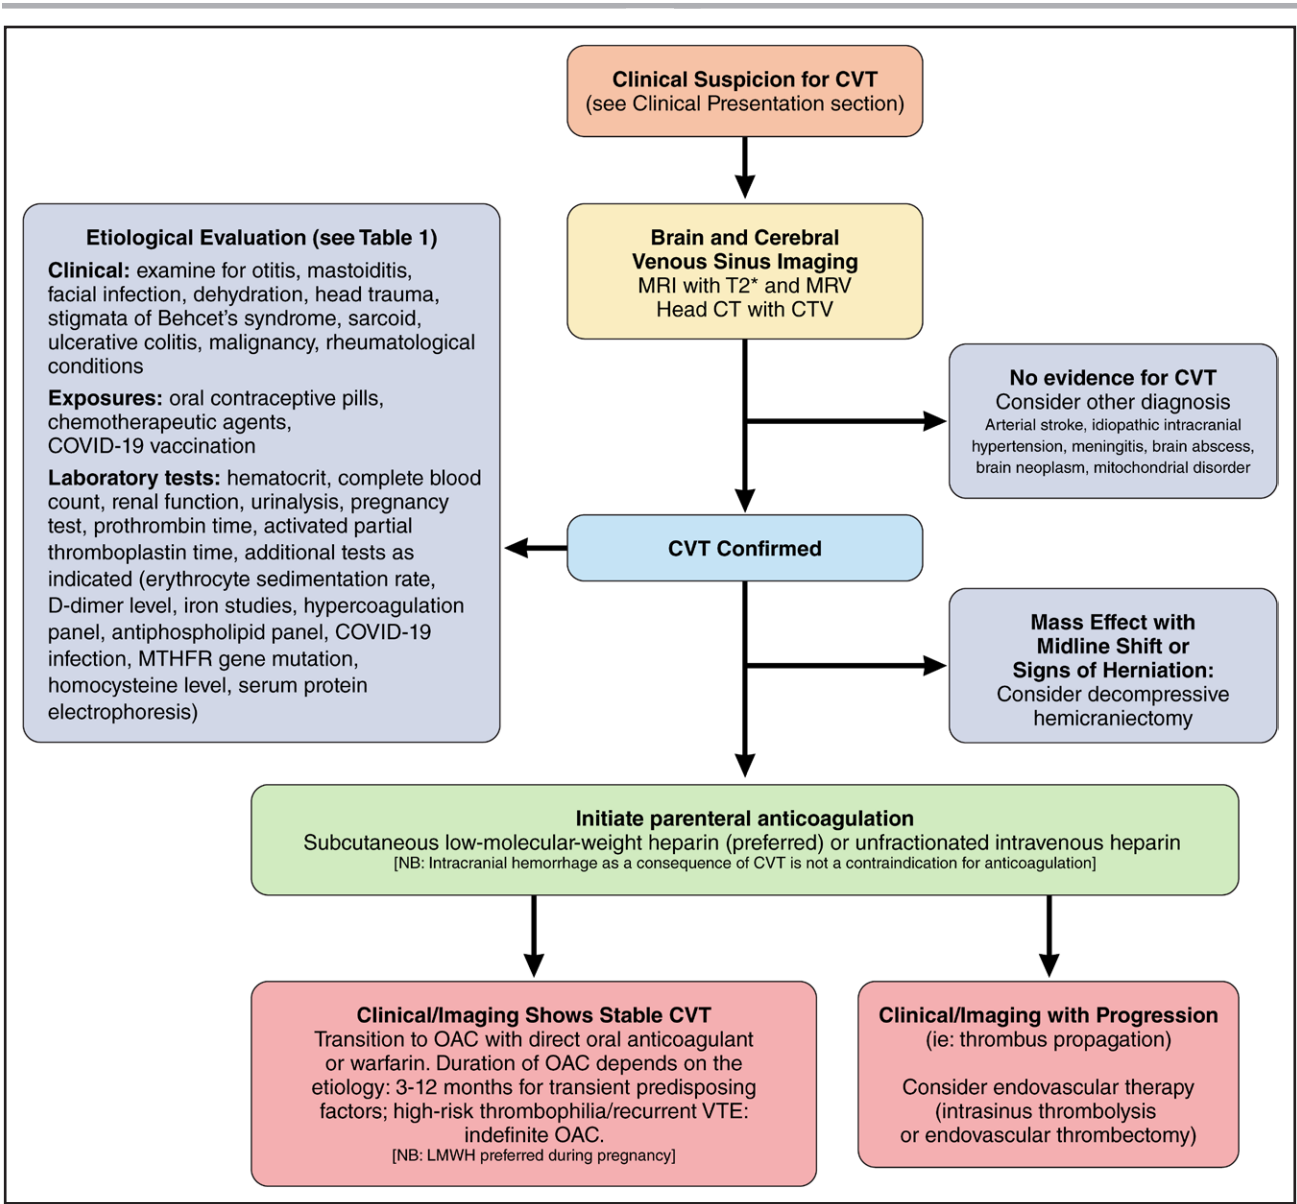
Proposed algorithm for the management of CVT. This figure summarizes the suggested approach for the diagnosis and management of CVT. CT indicates computed tomography; CTV, computed tomographic venography; CVT, cerebral venous thrombosis; LMWH, low-molecular-weight heparin; MRI, magnetic resonance imaging; MRV, magnetic resonance venography; OAC, oral anticoagulant; and VTE, venous thromboembolism.
